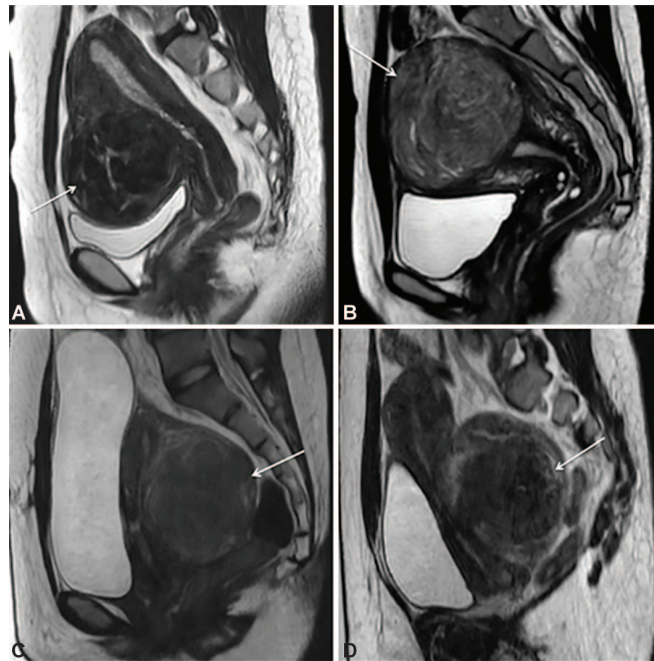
to D: Sagittal T2-weighted MRI showing uterine fibroid
